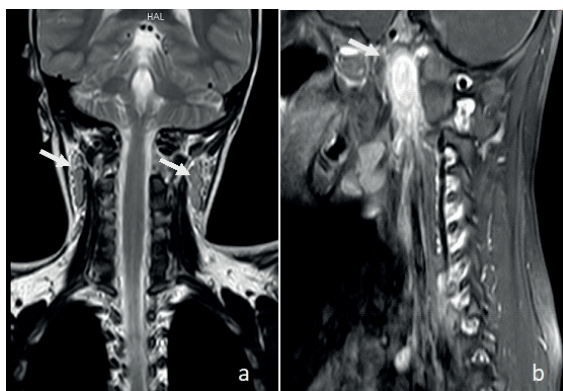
Fusiform shaped lymph nodes with thick cortices on the bilateral submandibular area in contrast enhanced cervical MRI coronal (a) and sagittal (b) sections (white arrows), and soft tissue inflammation showing the substance retention in the parapharyngeal area, can be observed (white arrow).
